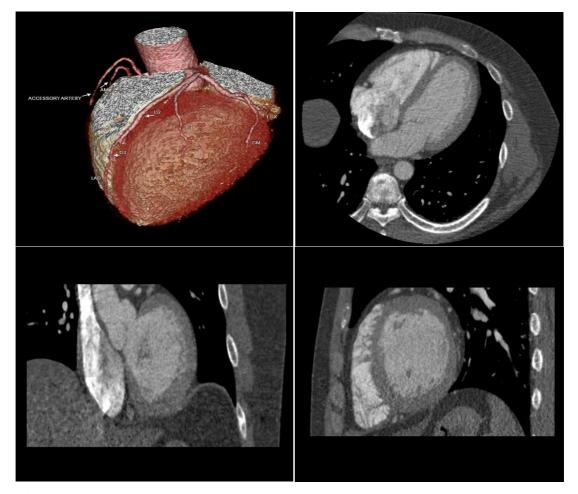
CT coronary angiogram image of a 45 years old male with history of chest pain taken in year 2016 using Toshiba Aquilion PRIME CT scanner
